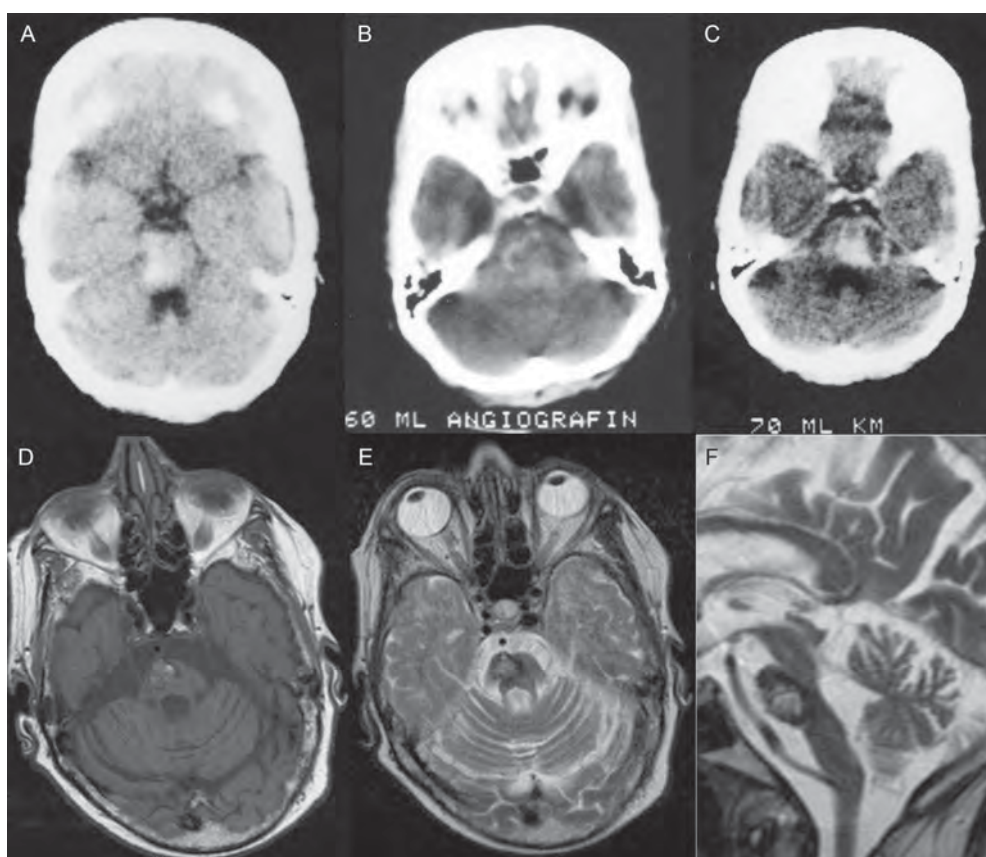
Axial CT-scan of the patient in 1978 without (A) and with contrast-enhancement (B). Repeated CT-scan in 1981 (C). Axial T1-, and T2-weighted (D, E) MRI scan in 2005 showing the brainstem cavernoma. Note the marked atrophy of the irradiated field on the sagittal T2-image (F).
